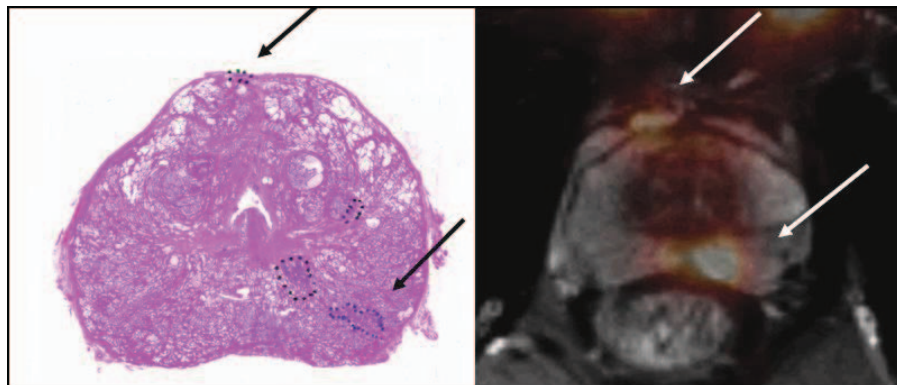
Fused ProstaScint and MRI images (right) demonstrating 2 areas of focal activity (white arrows) that correspond to step-sectioned pathologic presence of prostate cancer (black arrows, left). Circled areas without arrows represent inflammation. Courtesy of Rodney Ellis, MD, and Bruce Sodee, Case Western Reserve University, Cleveland, OH.
